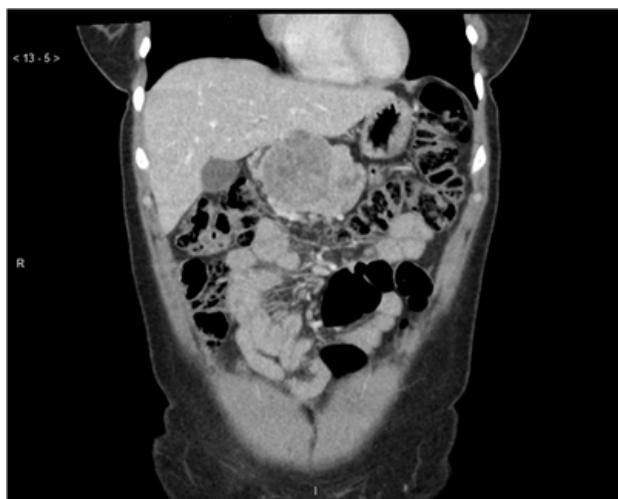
Abdominal CT showed a large and complex mass with heterogeneous enhancement by intravenous contrast on pancreatic head topography, measuring 7.8x5.5cm, associated with complete agenesis of the body and tail of the pancreas.
